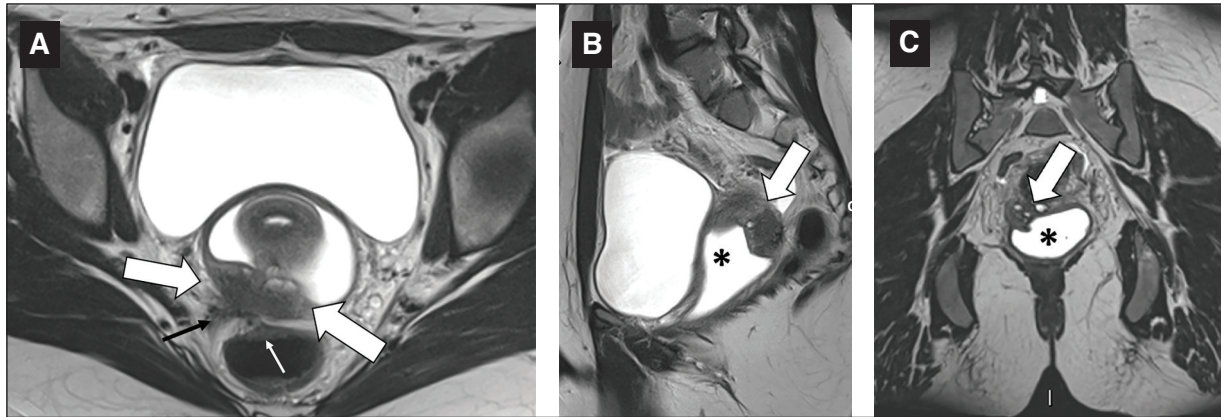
Endometriosis of the posterior compartment of the pelvis in a 41-year-old-woman with severe dyspareunia. A: axial T2-weighted MRI showing mixed thickening compromising the posterior vaginal wall associated with partial obliteration of the posterior vaginal fornix (white arrows). B and C: there is also thickening of the right uterosacral ligament insertion (thin black arrow) and anterior rectal wall (thin white arrow). Note that vaginal distension with US gel (asterisk) in sagittal and coronal T2-weighted MRI better demonstrates the vaginal lumen and the nodular vaginal thickening (arrows).
